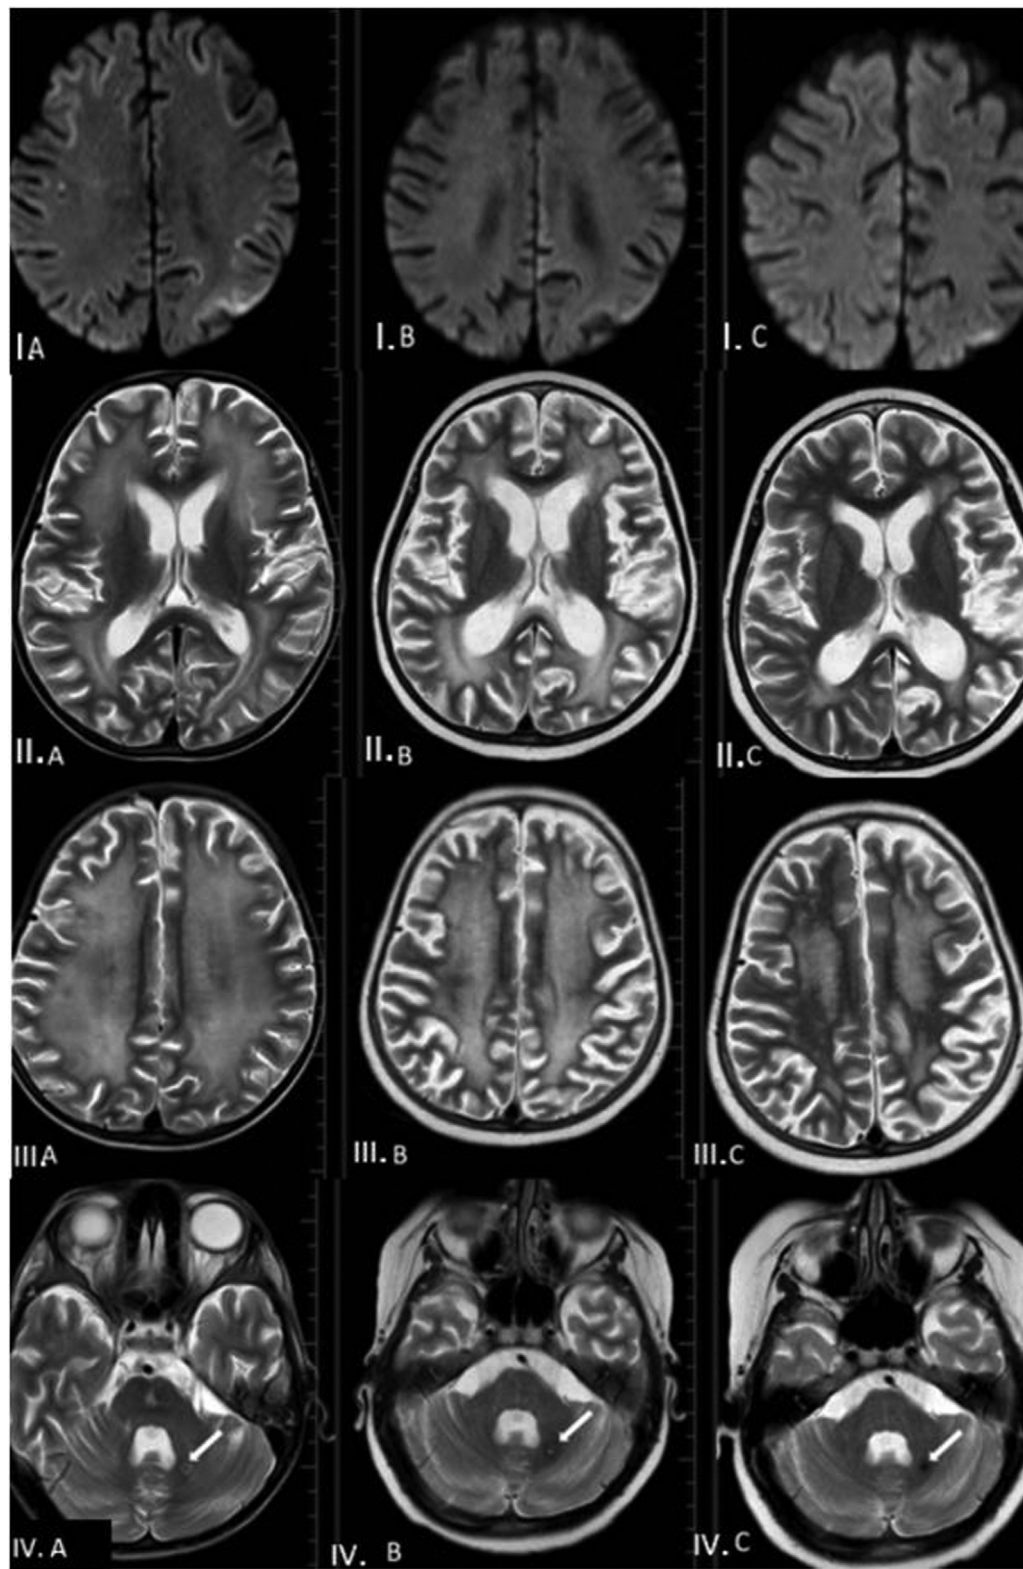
Case 1: (IA) Initial magnetic resonance imaging (MRI) showing restricted diffusion in subcortical U fibers of bilateral frontal, parietal and occipital cortices, (IB) Pre-hematopoietic stem cell transplantation (HSCT) MRI showing regression of the same, (IC) MRI post 6 months HSCT showing resolution of the same. (IIA) Initial MRI showing normal ventricles, sylvian fissures, cortical sulci and cisternal spaces, (IIB) Pre-HSCT MRI and (IIC) MRI post 6 months HSCT showing minimal dilatation of all ventricles, sylvian fissures, cortical sulci and cisternal spaces. (IIIA) Initial MRI showing increased signal intensity on T2-weighted and fluid-attenuated inversion recovery imaging in periventricular white matter of bilateral cerebral hemispheres. (IIIB), Pre-HSCT MRI and (IIIC) MRI post 6 months HSCT showing regression of the same. (IVA) Initial MRI showing hemorrhagic lesion in left cerebellum (white arrow), (IVB) Pre-HSCT MRI and (IVC) MRI post 6 months HSCT showing further regression of the same.
